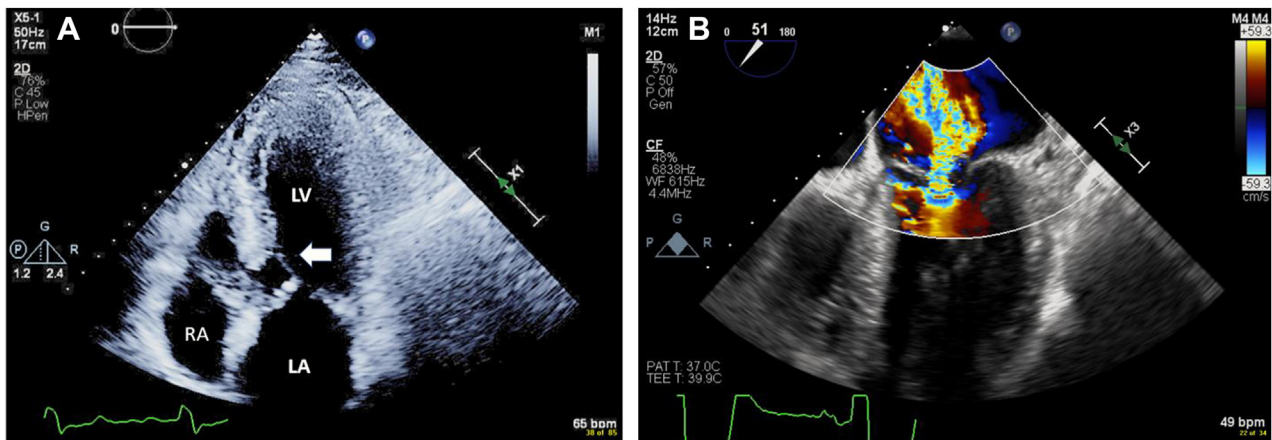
Case 2: (A) Two-dimensional TTE, apical four-chamber systolic view, demonstrates SAM of the anterior MV leaflet (arrow) and a dilated left atrium (LA). (B) Two-dimensional TEE with color flow Doppler, midesophageal long-axis (51°) view, demonstrates at least moderate MR with significant proximal flow acceleration and vena contracta. LV, Left ventricle; RA, right atrium.
